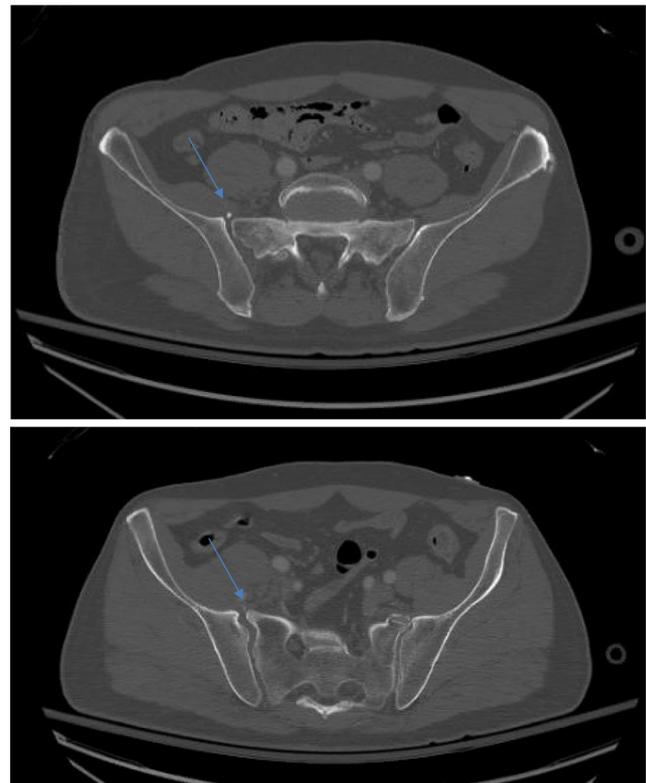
Axial computed tomography sections of two different patients demonstrating the “fleck” sign as a potential radiographic marker demonstrating lateral compression type injury with potential for unrecognized rotational injury of contralateral hemipelvis
